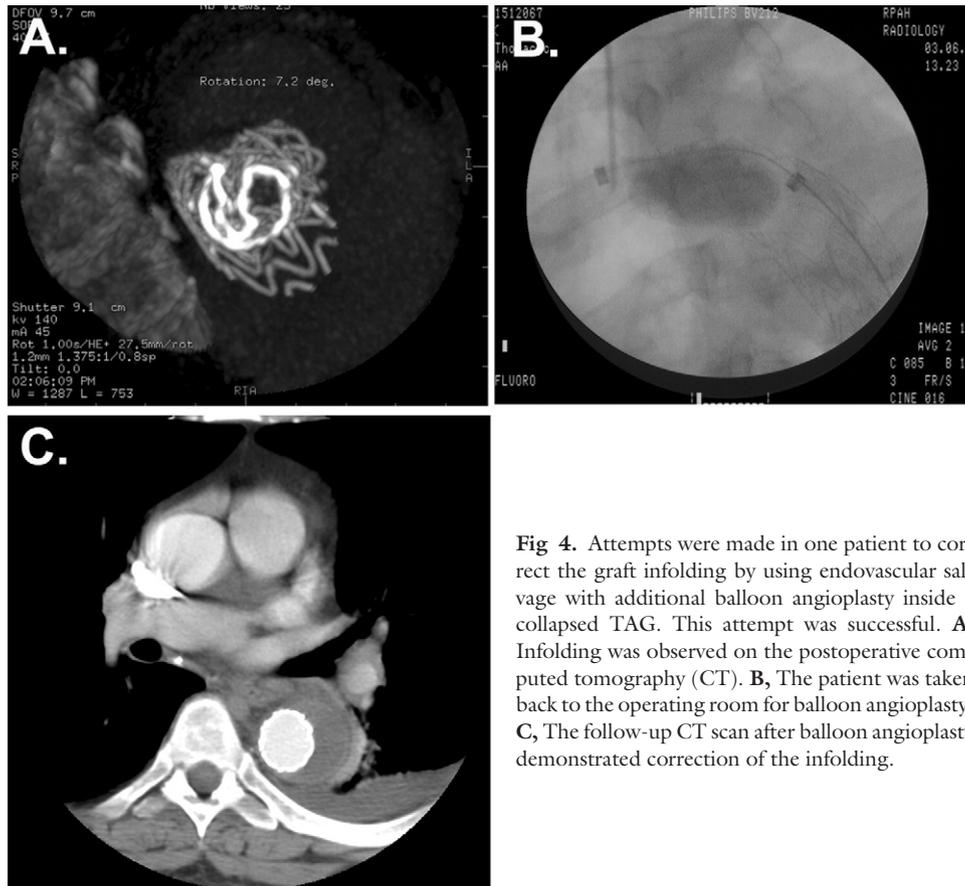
Attempts were made in one patient to correct the graft infolding by using endovascular salvage with additional balloon angioplasty inside a collapsed TAG. This attempt was successful. A, Infolding was observed on the postoperative computed tomography (CT). B, The patient was taken back to the operating room for balloon angioplasty. C, The follow-up CT scan after balloon angioplasty demonstrated correction of the infolding.
